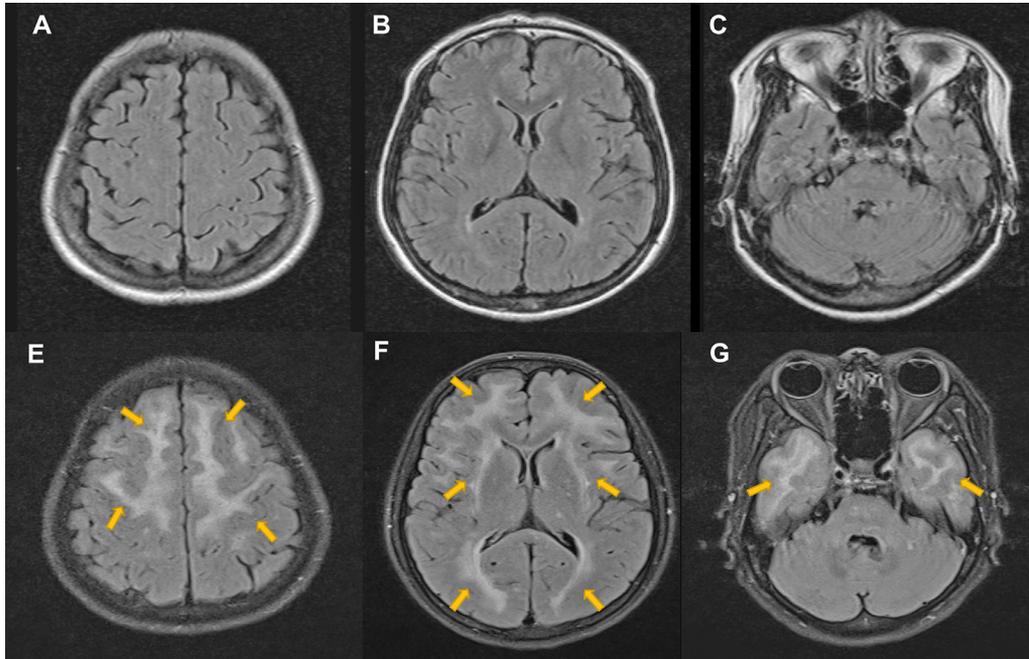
Comparison of the brain MRI obtained between the fourth (A–C) and fifth attacks (D–F), with an asymptomatic twelve-year interval, revealed striking white matter hyperintensities involving the subcortical and deep white matter, external capsules, deep gray matter, anterior temporal lobe, and pons (arrows).
